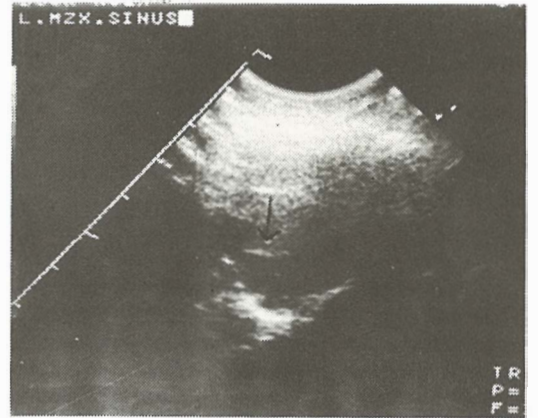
Ultrasound finding of the maxillary sinus, with fluid level
